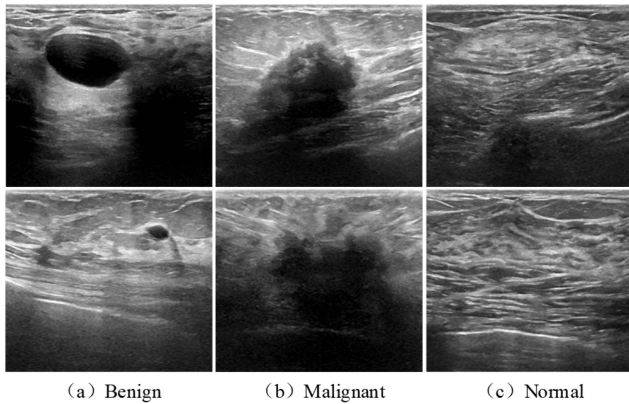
Representative images from the breast ultrasound image dataset.
